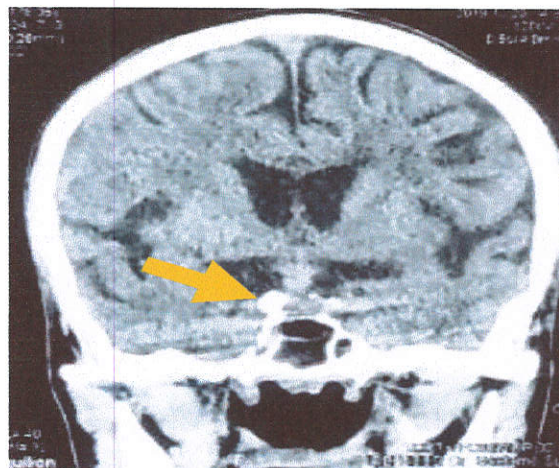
MRI results before the EETA procedure
